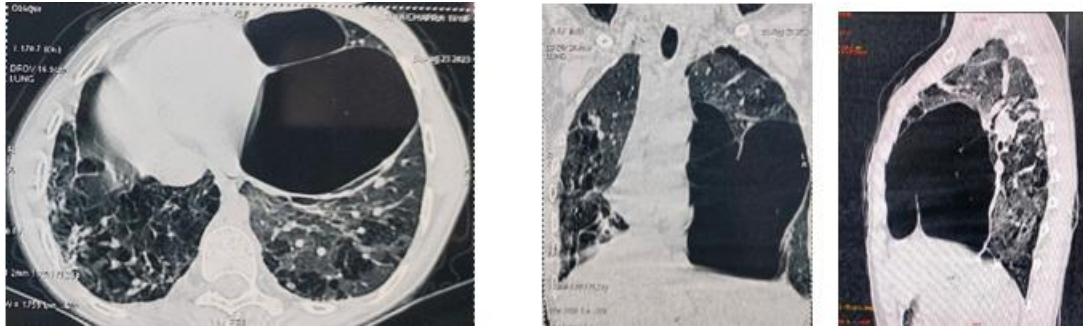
4: HRCT: Emphysematous bullae in both lung fields, largest one measuring approximately 123*101*91 mm in left lung with shift of mediastinum towards right side.
